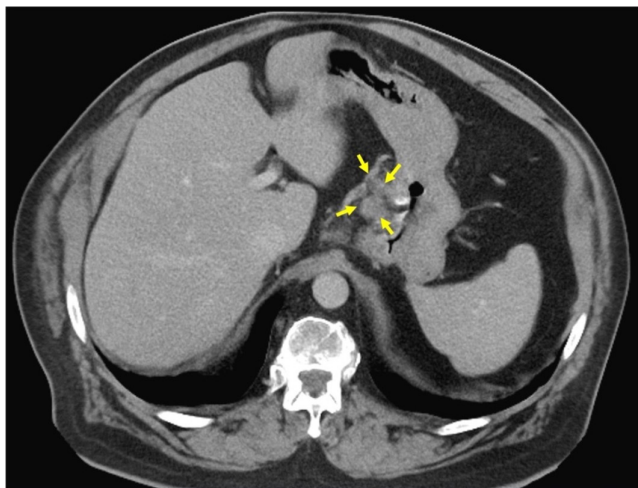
Cross-sectional imaging (CT scan) showing large peri gastric lymph nodes measuring 2–2.5 cm in the setting of esophageal cancer.
